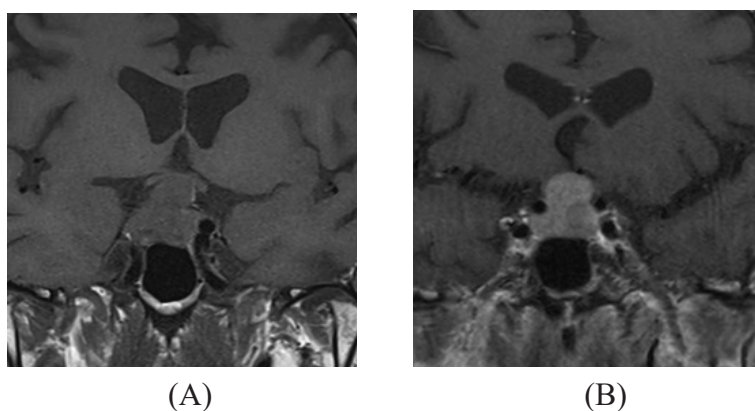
Coronal T1-weighted MRI Comparison Over Time. (A) Initial Scan Demonstrating a Pituitary Macroadenoma. (B) Three-Year follow-up Showing Interval Enlargement to 24 × 25 × 16 mm (Previously 20 × 25 × 16 mm), Indicating Slight Progression along the Craniocaudal Axis.
